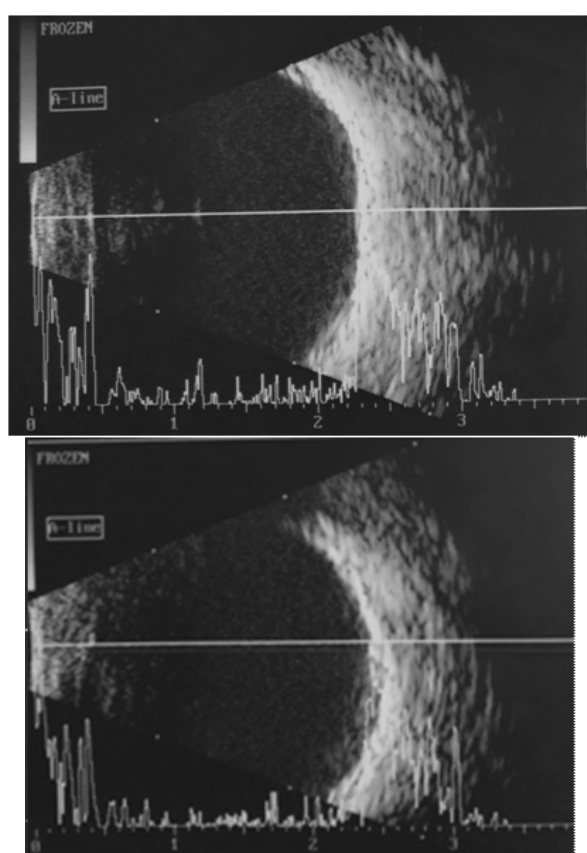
Ocular ultrasonography.
